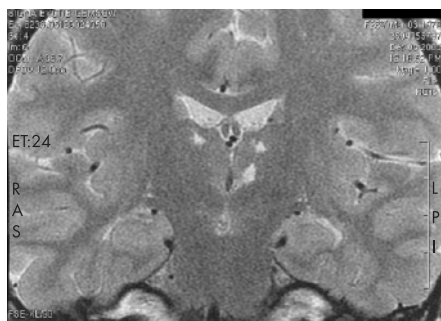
Brain MRI. T2 weighted coronal section shows bithalamic small infarcts, as fluid T2 hyperintensities, of the dorsolateral and left centromedial nuclei.
